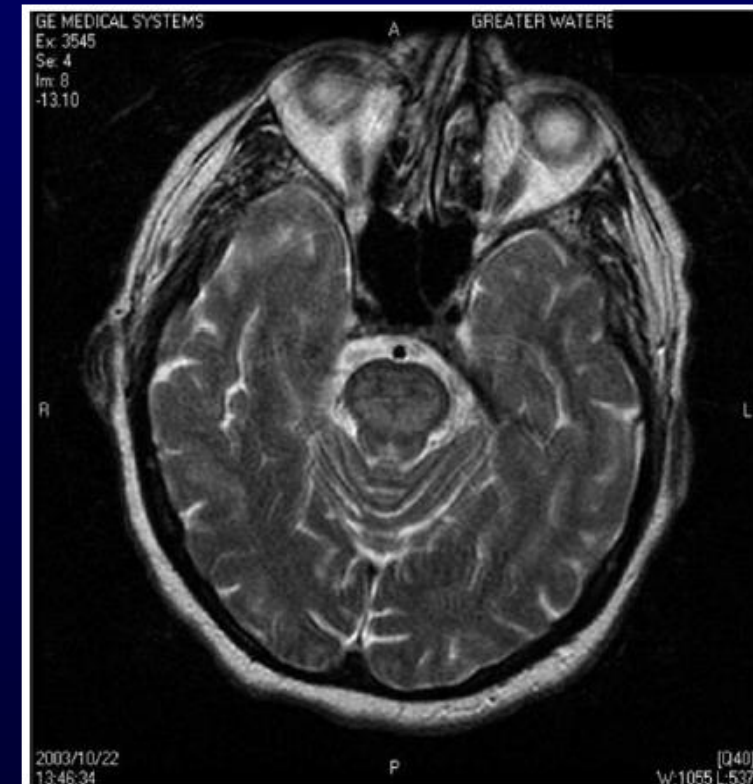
Magnetic resonance image of the brain on day 12 shows pontine myelolysis.
